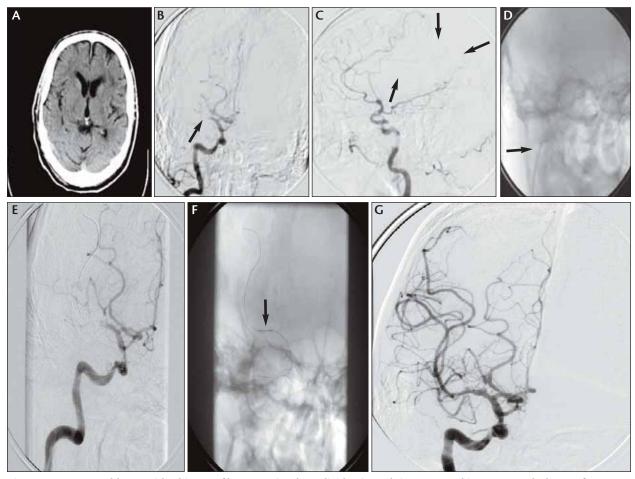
A 71-year-old man with a history of hypertension, hyperlipidemia, and cigarette smoking presented 4 hours after onset of a dense left hemiparesis, hemianopsia, and right gaze deviation. His NIHSS score was 18, consistent with a right MCA. A non-contrast CT of the brain showed no evidence of acute ischemia (A). Emergent angiography was performed revealing a mid-right MCA trunk occlusion (arrow), which is best seen in the anteroposterior cranial view (B). The lateral image does not show the site of occlusion but shows the anterior and posterior cerebral artery territories well, and the lack of flow to the MCA cortical branches (arrows) (C). A 6-F guide catheter could only be advanced into the midcervical internal carotid due to the tortuosity (arrow) (D). Through the guide, a 2.3-F microcatheter was advanced over a .014-inch wire into the thrombus, and through it, 25 mg of tPA was infused over 30 minutes with no improvement in flow (E). The microcatheter was exchanged over the wire for a 1.5- X 9-mm balloon that was used to angioplasty the MCA twice. A waist (arrow) is clearly seen on the balloon, suggesting the presence of an underlying atherosclerotic lesion rather than an embolism (F). Partial recanalization was achieved, but the vessel reoccluded almost immediately. Therefore, the balloon was exchanged for the microcatheter through which 6 mg of abciximab was infused into the MCA. This was followed by almost immediate recanalization, although an underlying stenosis is clearly visible on the final anteroposterior angiogram (G). The flow was markedly improved, so no further intervention was performed. The patient was monitored closely without additional antithrombotics for 24 hours and made a nearly complete recovery.
